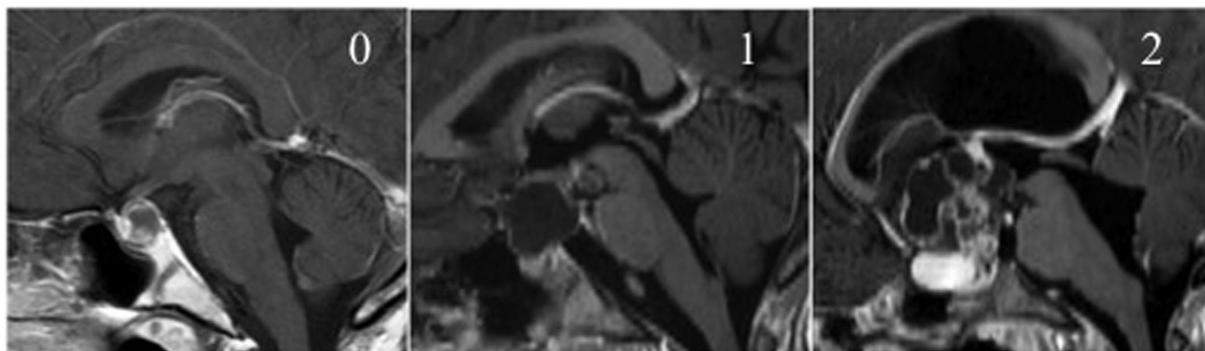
Pre-operative MRI classification according to hypothalamic involvement. Type 0 pre-op: no involvement of the hypothalamus, Type 1 pre-op: distortion/elevation of the hypothalamus, Type 2 pre-op: the hypothalamus is not visible due to tumor invasion.
